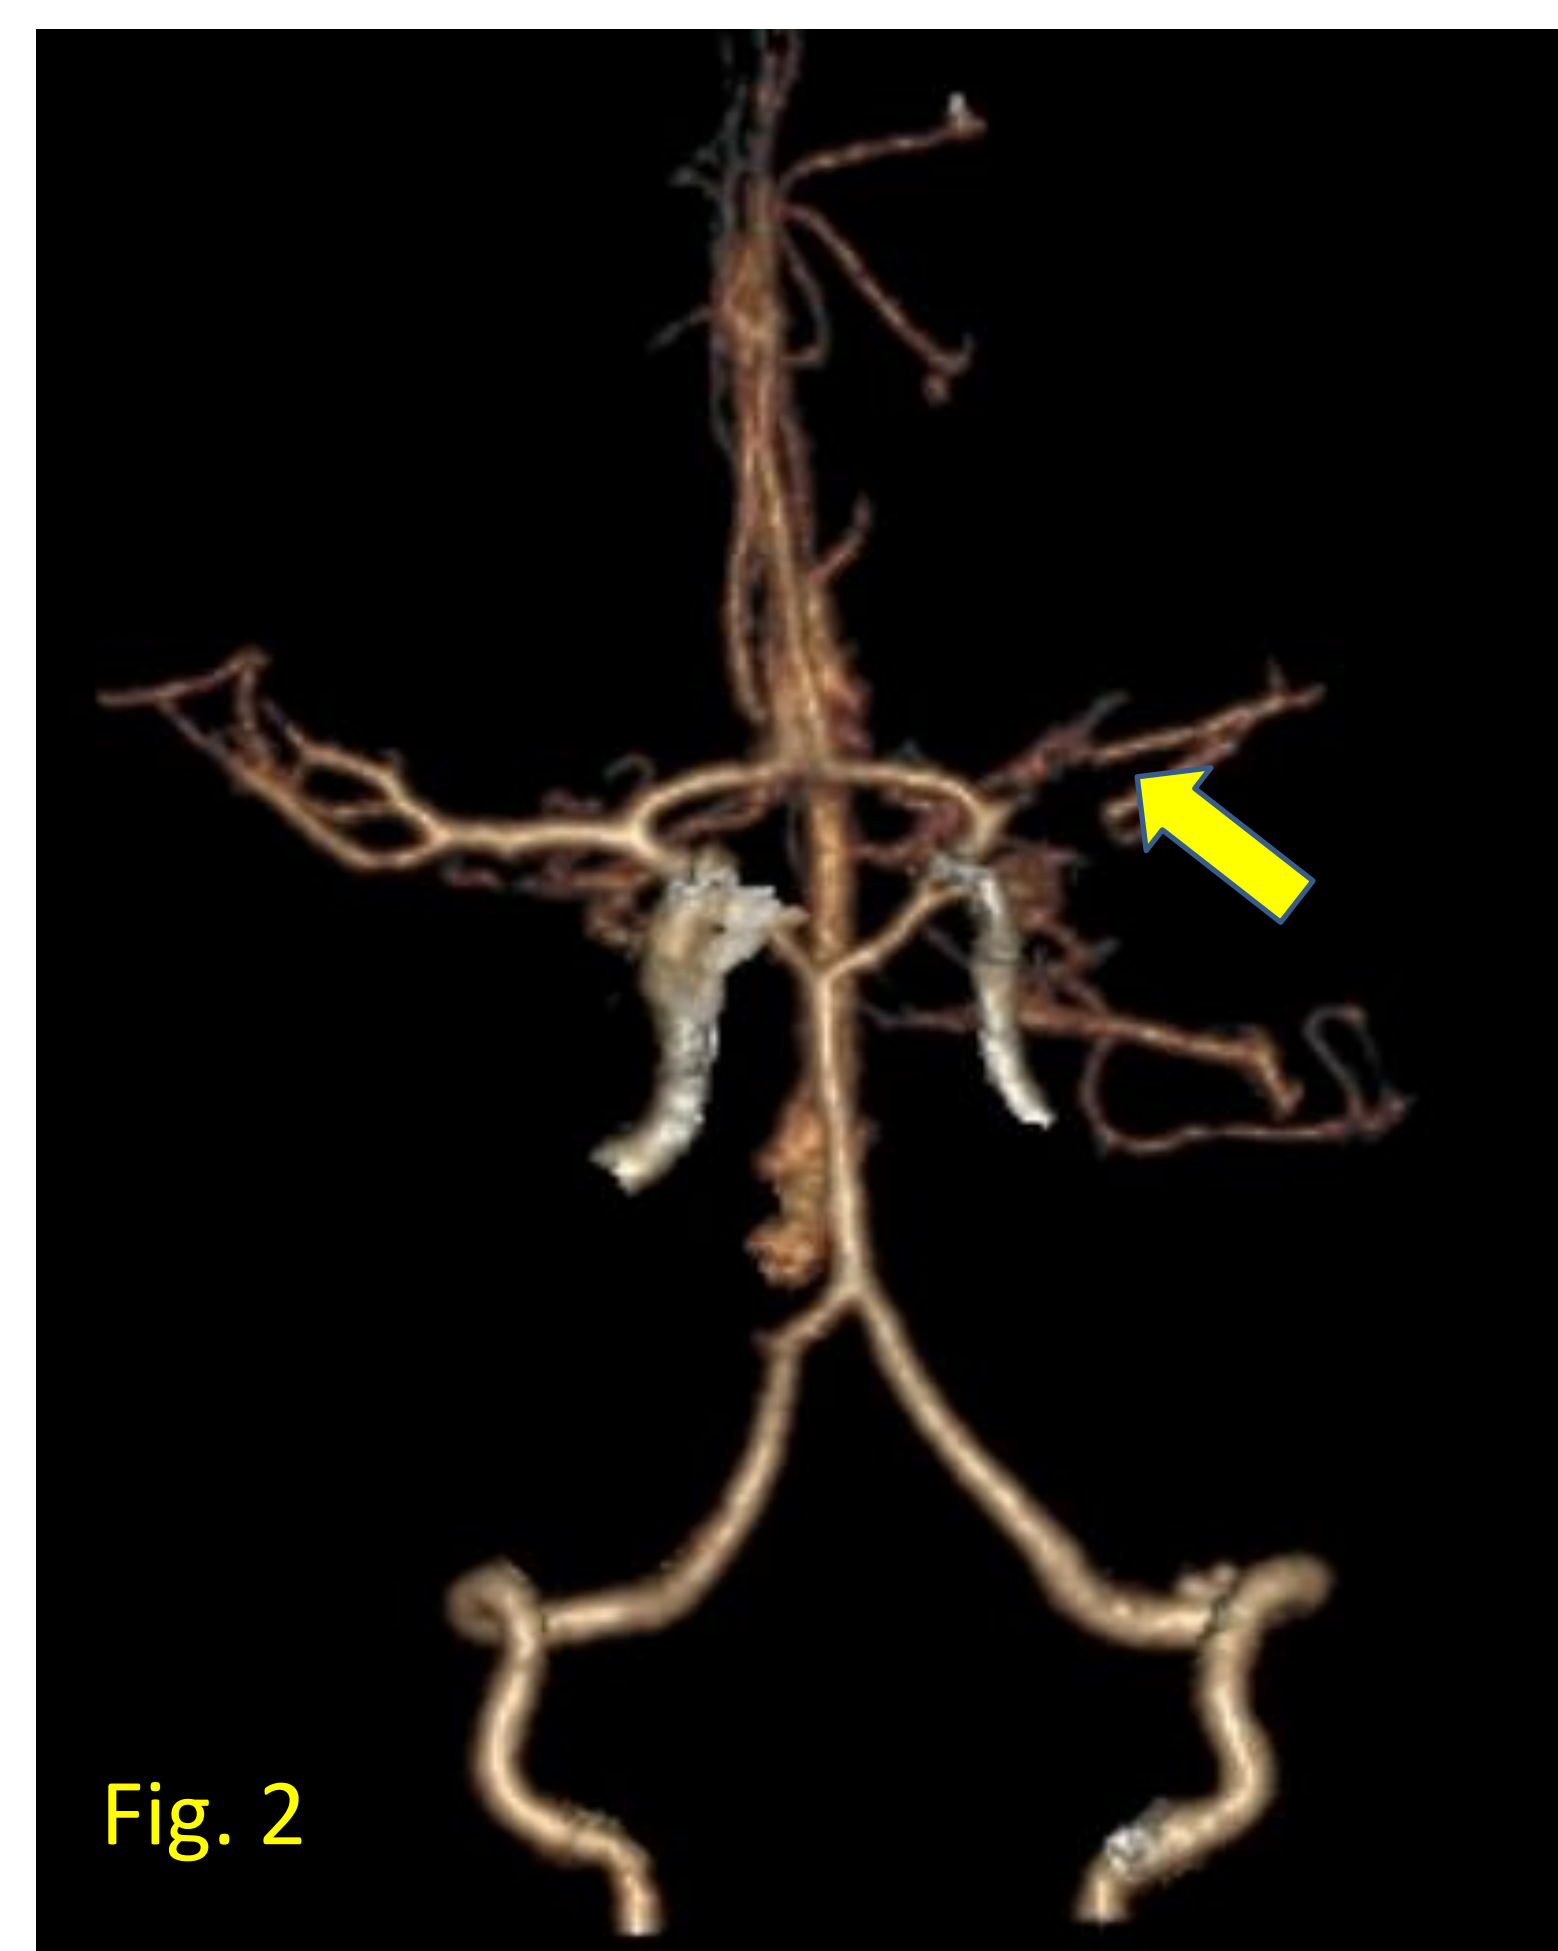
CTA of head significant for left M1 segment middle cerebral artery demonstrates high-grade stenosis estimated at between 60 and 75%.
